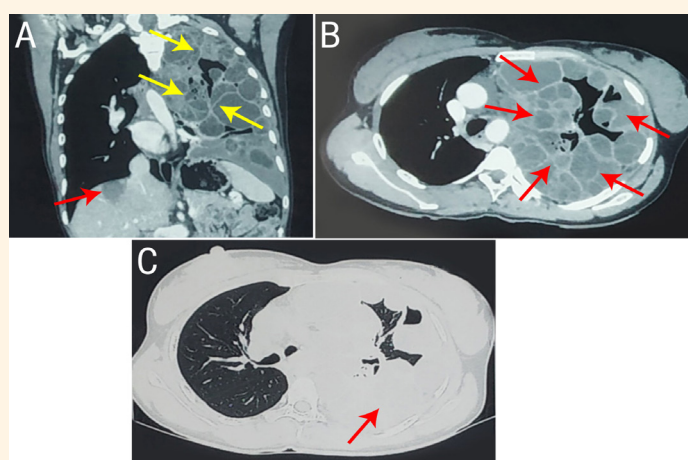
A: Contrast enhanced computed tomography (CECT) thorax coronal view showing multiple intrathoracic cystic lesions with thickened septa (yellow arrows) and hepatic cyst (red arrow). B: CECT thorax axial view showing interconnected cystic lesions (arrows) with mediastinal shift to the opposite side. C: Axial view of upper lobes with lung window showing consolidation of the left lung (arrow) with minimally visible parenchymal markings.
